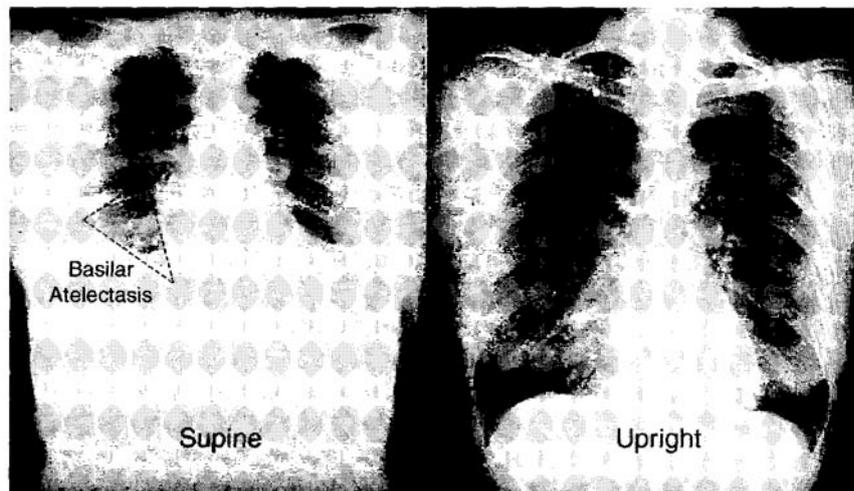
The effect of body position on the appearance of portable chest x-rays. Both images were obtained within minutes of each other in the same patient. The dotted triangle outlines an area of localized atelectasis that could be misread as a basilar pneumonia. Image on the left digitally enhanced.
